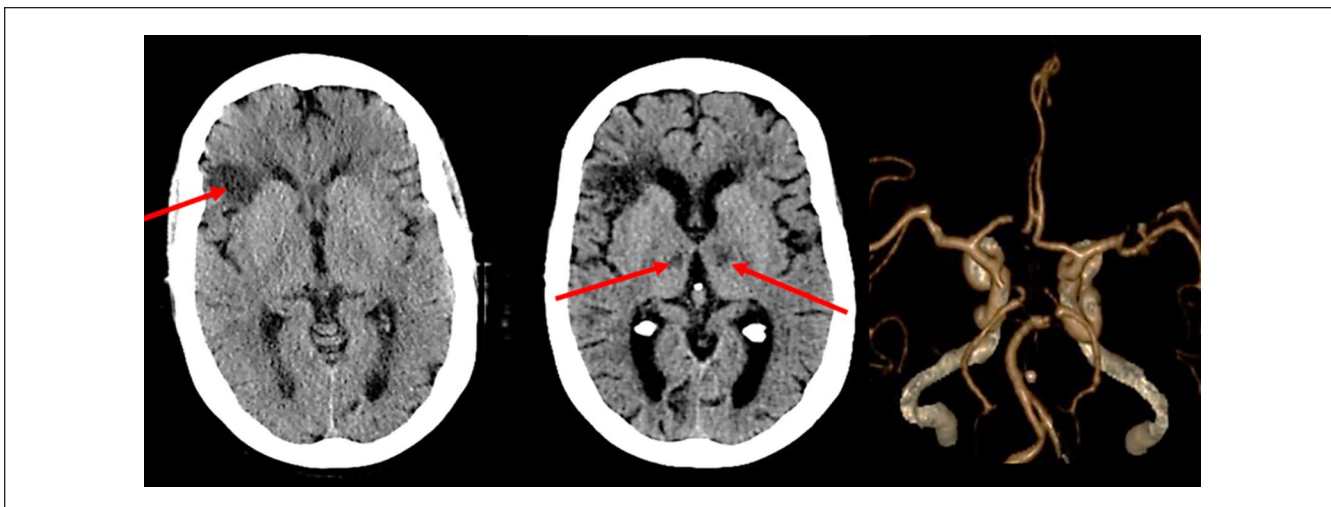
Initial computed tomography (CT) scan of the head (left) showed an area of encephalomalacia in the right frontal lobe (arrow) consistent with an old stroke. Repeat CT scan of the head (middle) 12 hours after the initial CT scan revealed acute infarcts in the paramedian zone of the thalami (arrows) and CT angiogram (right) showed filling defects at the top of the basilar artery and the P1 segments of the posterior cerebral arteries.
